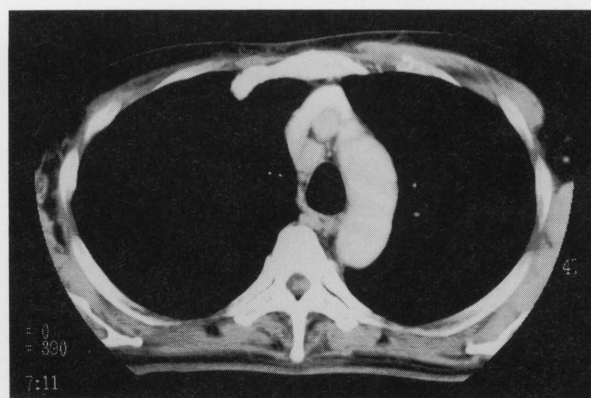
Computed tomography of the chest taken with the scintigraphic information demonstrated a mass (arrow) measuring 15 mm in diameter adjacent to the superior vena cava.
